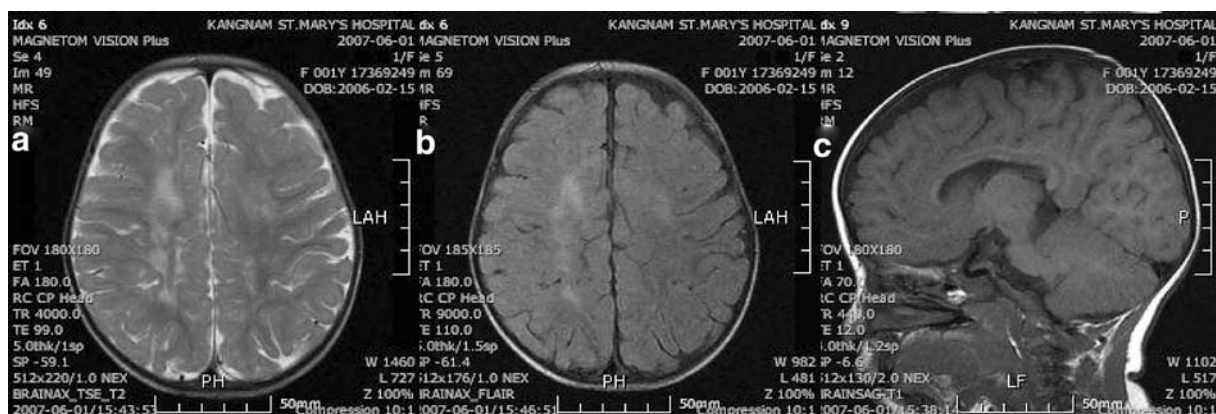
At 15 months of life, axial T2-weighted (TR/TE, 9,000/110) and flare MR images (TR/TE, 4,000/99) showed high-signal areas in the periventricular white matter of the cerebral hemispheres, suggesting
